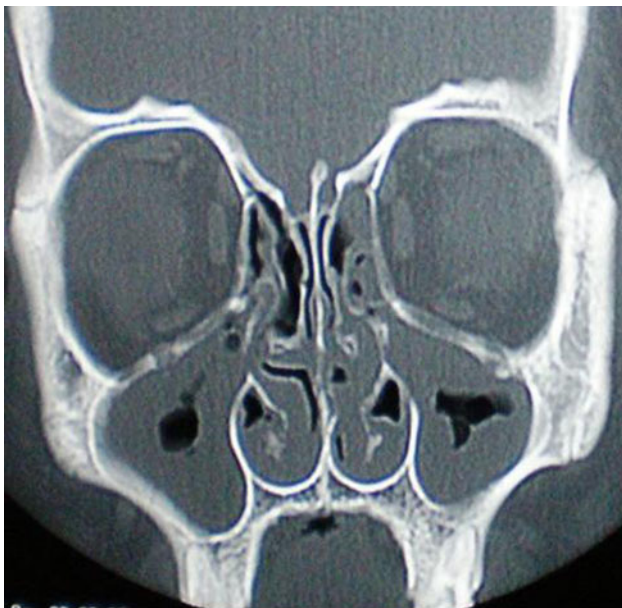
Maxillary sinusitis: pre-operative CT scan
